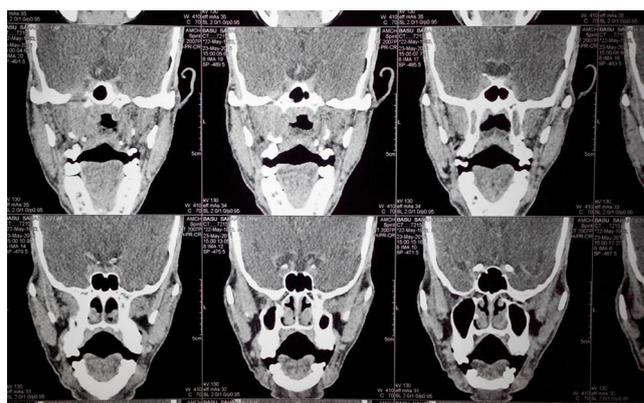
CT scan of head and neck region
